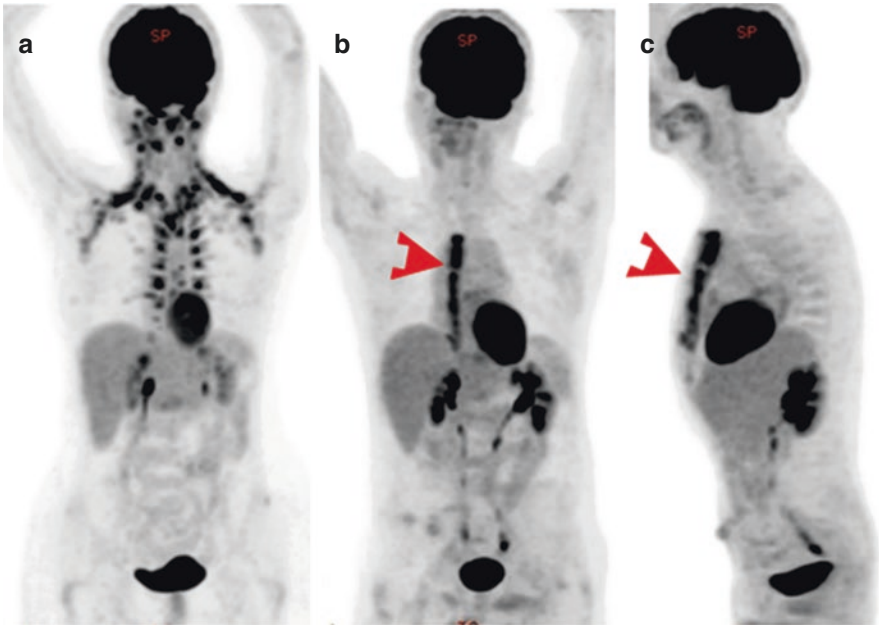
Maximum intensity projection (MIP) ^{18}F -FDG PET images demonstrate (a) physiological brown fat uptake in the neck, supraclavicular fossae, mediastinum and suprarenal region, (b, c) intense tracer uptake in the sternum in patient with recent sternotomy (arrowheads)
